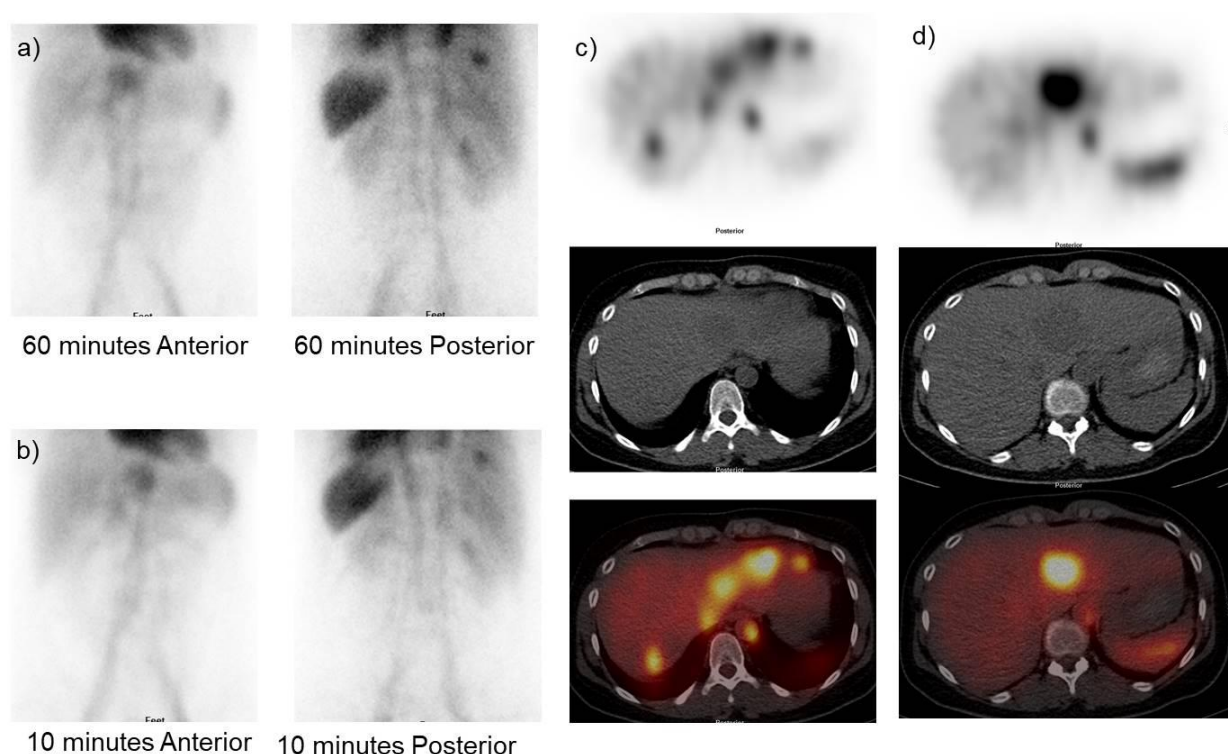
^{99m}Tc RBCs Labelled Scan of the Liver a-b) 60 and 10minutes static images c-d) SPECT/CT images
